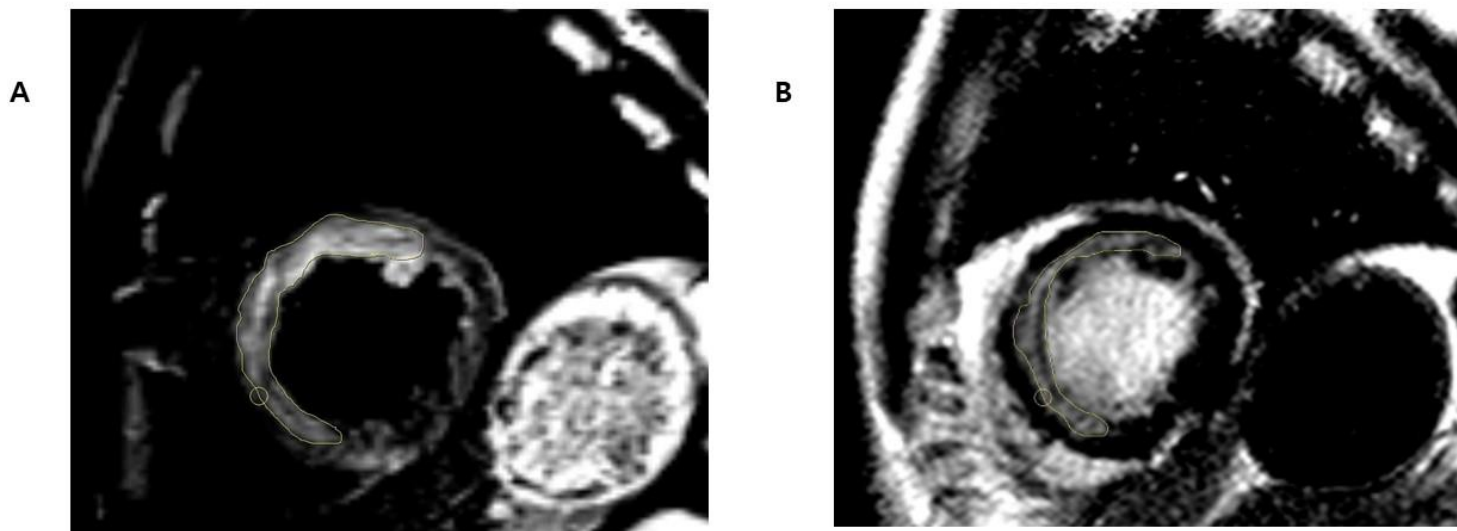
Short-axis contrast-enhanced magnetic resonance images. T2-weighted short-axis image showing edema (A) and the corresponding delayed enhancement (85% of transmural) and microvascular obstruction (MVO) (B).
